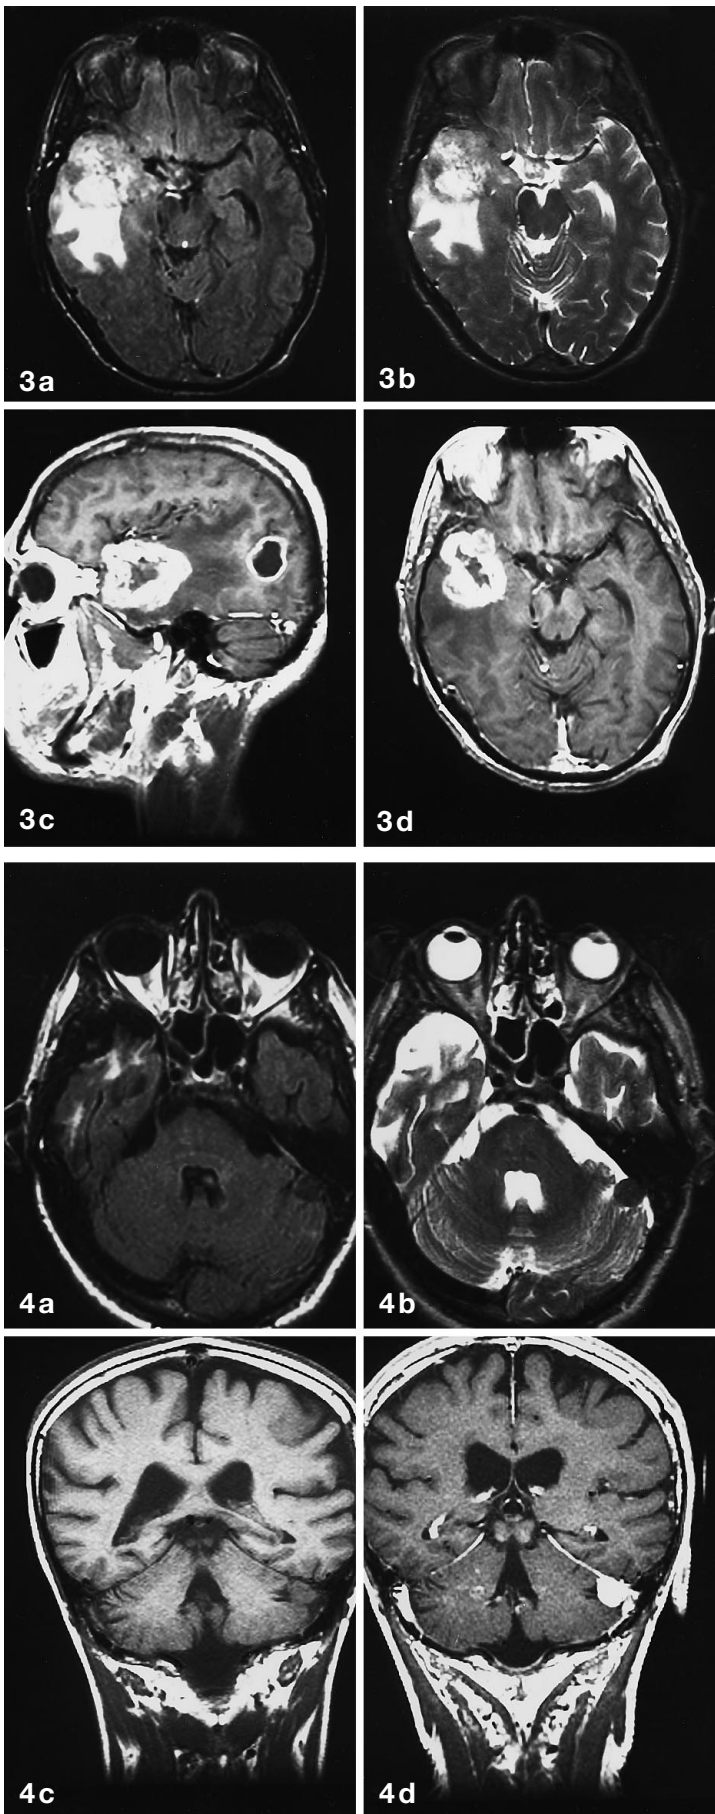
Astrocytoma with poor contrast enhancement. a T2-weighted fast spin-echo (SE) image (TR/TE = 4000/108 ms); b fast-FLAIR image (TR/TE = 11,002/132/2600 ms); T1-weighted SE c pre- and d post-contrast images (TR/TE = 600/15 ms). The tumor is better defined on the fast-FLAIR series than on T2-weighted images. On the T1 post-contrast image, the tumor is more difficult to differentiate due to its signal intensity which is almost identical to brain tissue
